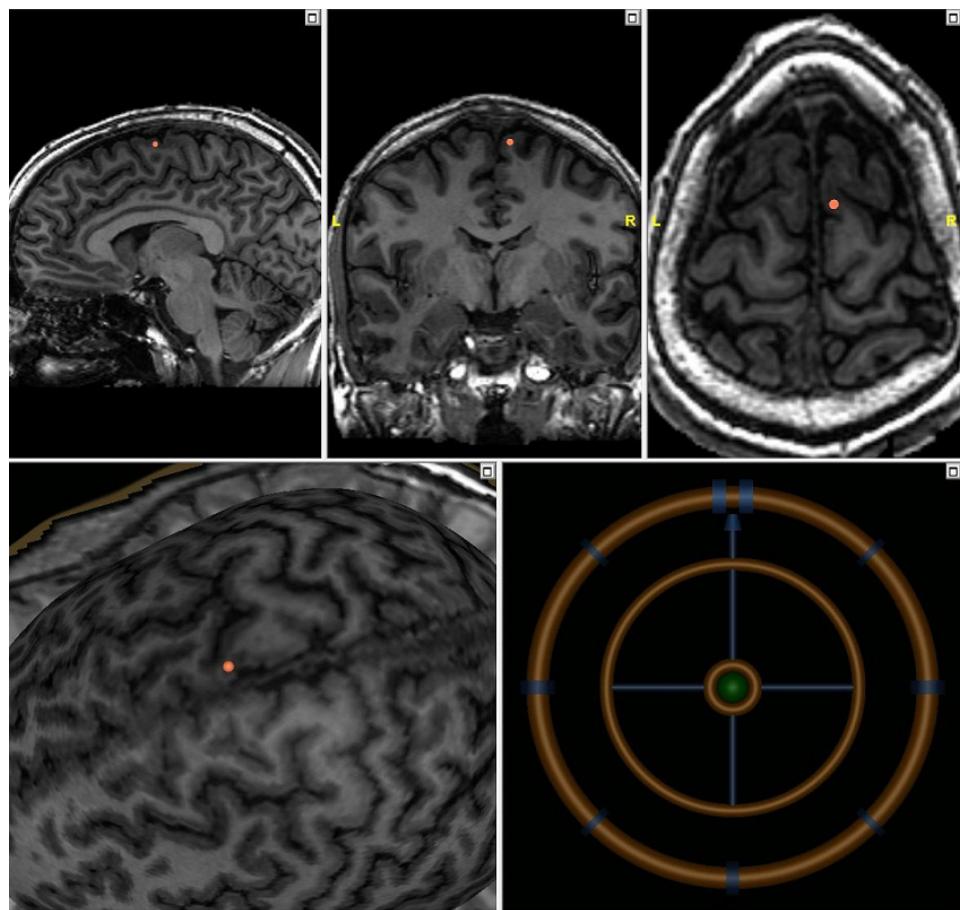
Stimulation target displayed on the MR images and 3D head
